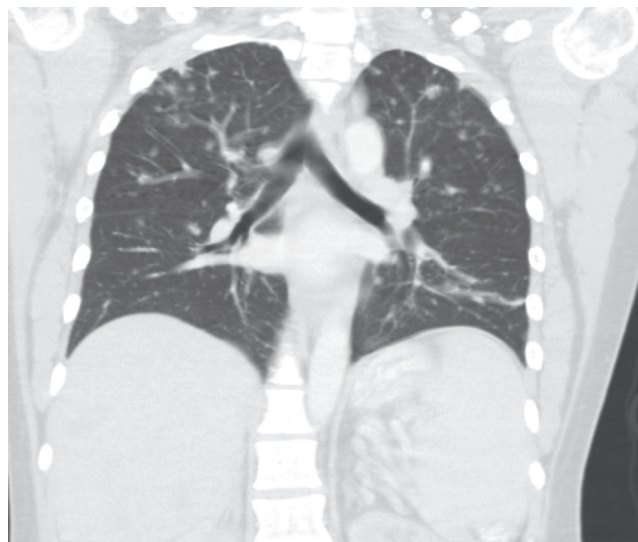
■ Computed tomography of the chest from a patient with pulmonary Langerhans cell histiocytosis.
